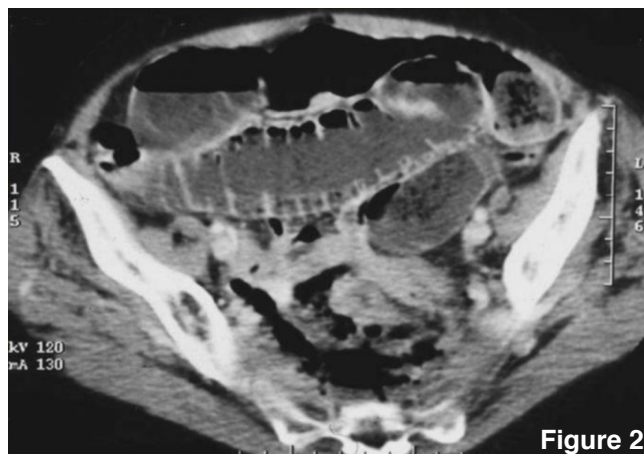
Abbreviations: CT, computed tomography
